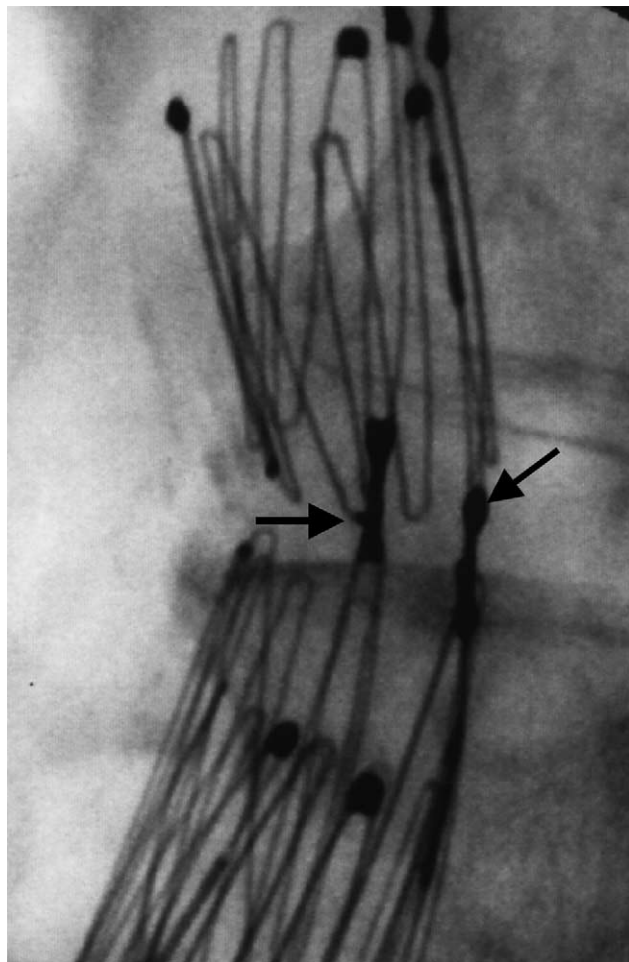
Roentgenogram of endoskeleton. Partial attachment of stents (arrows) increases flexibility for the endoskeleton to fit aortic tortuosity.
